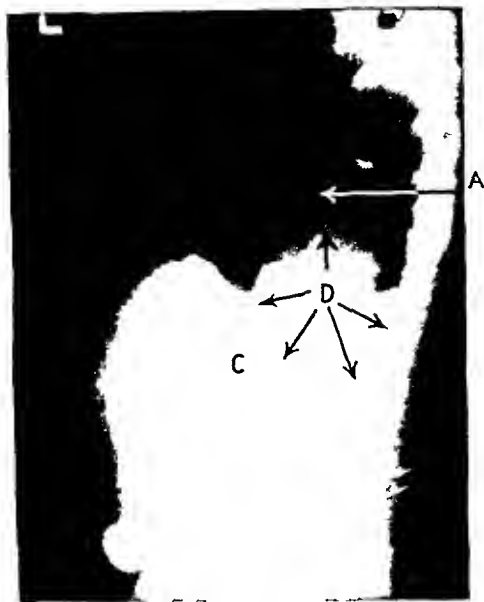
Left lateral radiograph following barium meal, showing relation of abscess to stomach and colon. A Elevated left diaphragm, B, Gas in stomach, C, Gas in colon, D, Abscess
